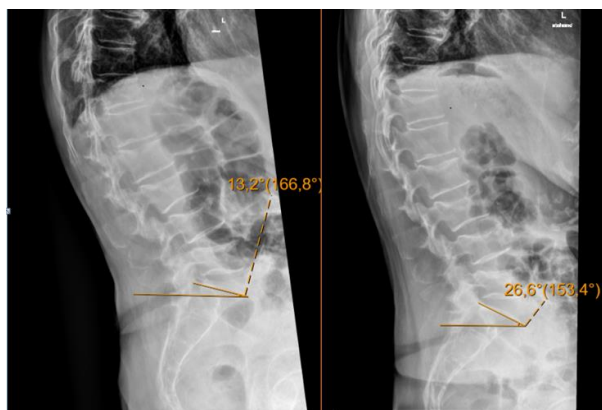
Standing lumbar X-Ray demonstrates the marked improvement of Sacral Slope and other pelvic Parameters , Left: prior therapy, right: after Pain therapy.
